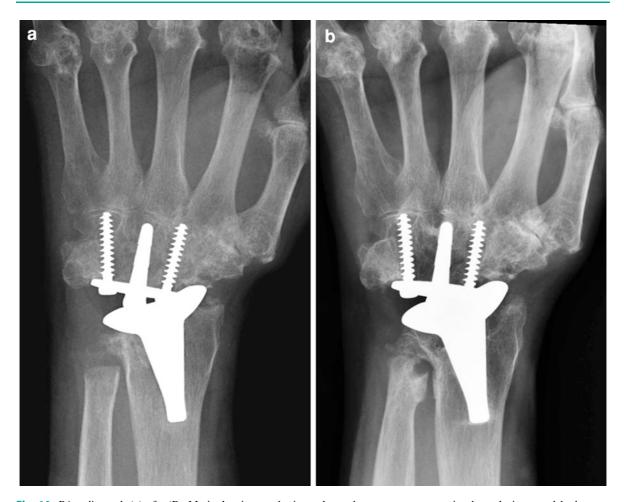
PA radiograph (a) of a 'Re-Motion' wrist prosthesis, in a patient with severe rheumatoid arthritis. The prosthesis is angulated and there is reasonable bone density around the wrist. Although there is no subsidence or change in position of the prosthesis, a follow up radiograph (b) acquired 3 years
